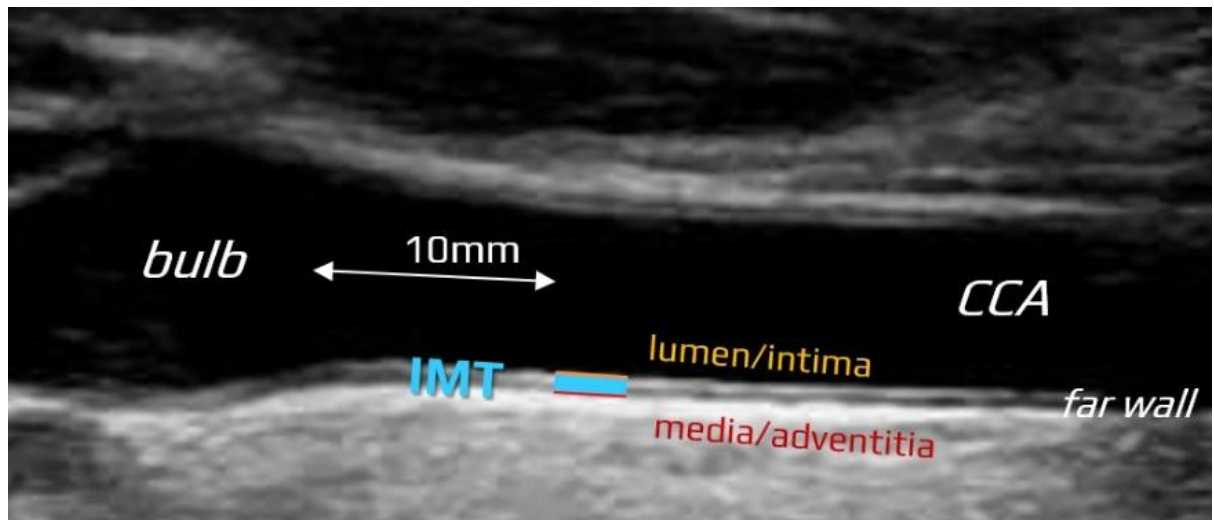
cIMT Measurement by Carotid Doppler Ultrasound
